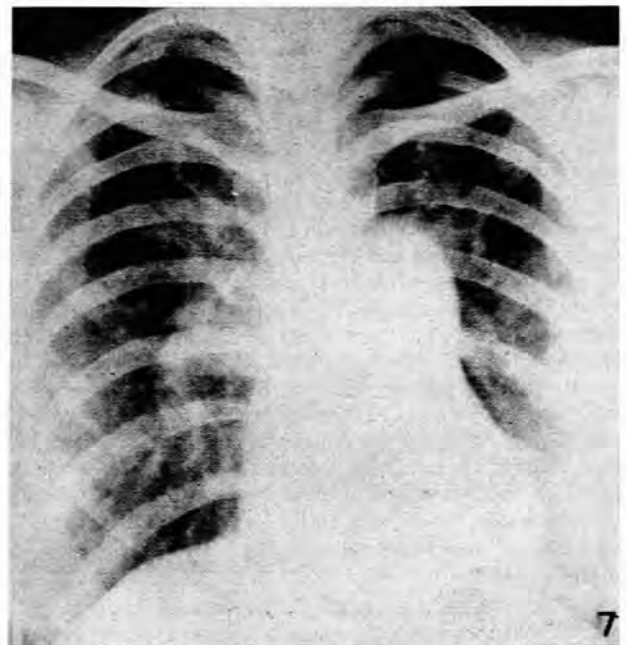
Radiograph showing striking attenuation of peripheral pulmonary arteries in a patient with severe pulmonary hypertension.
